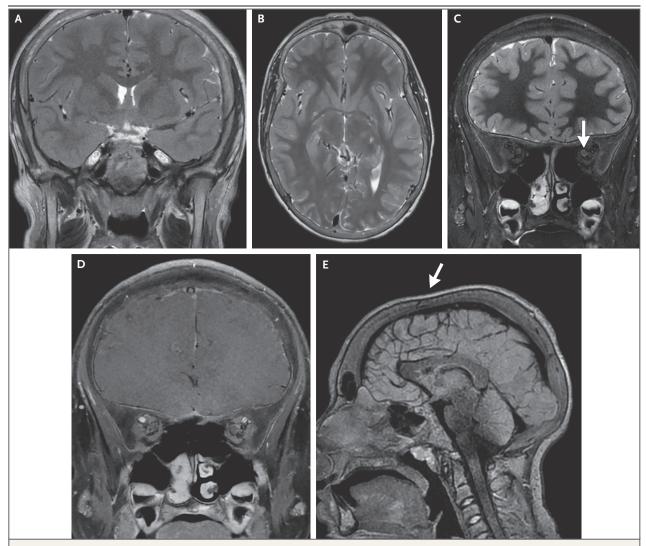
MRI of the Head and Orbits.
